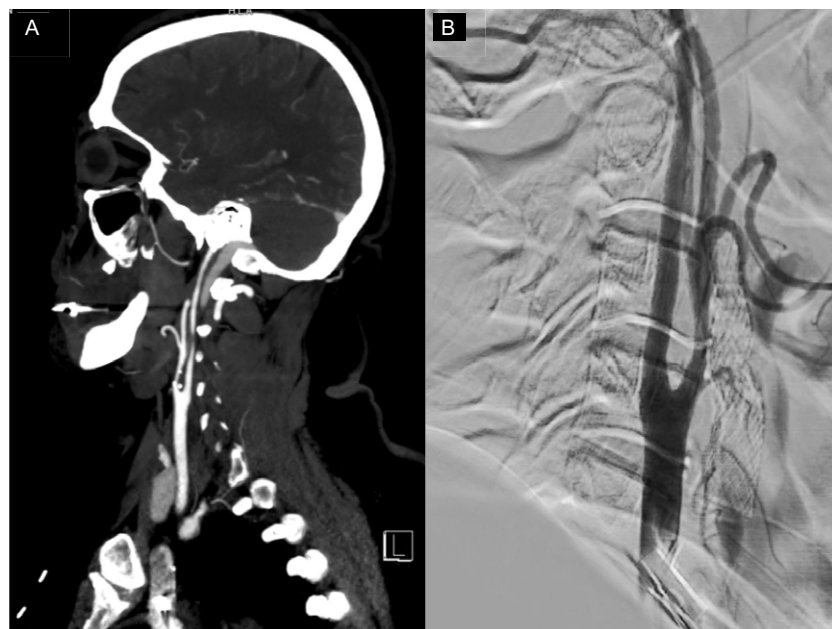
Imaging of patient presenting with recurring episodes of right monocular vision loss accompanied by transient right-sided facial and arm weakness in July 2024. (a) Cranial CT/CT angiogram showing severe (greater than 70%) stenosis of the right mid-cervical internal carotid artery (ICA). (b) Cerebral angiogram showing resolution of the right mid-cervical ICA stenosis.
